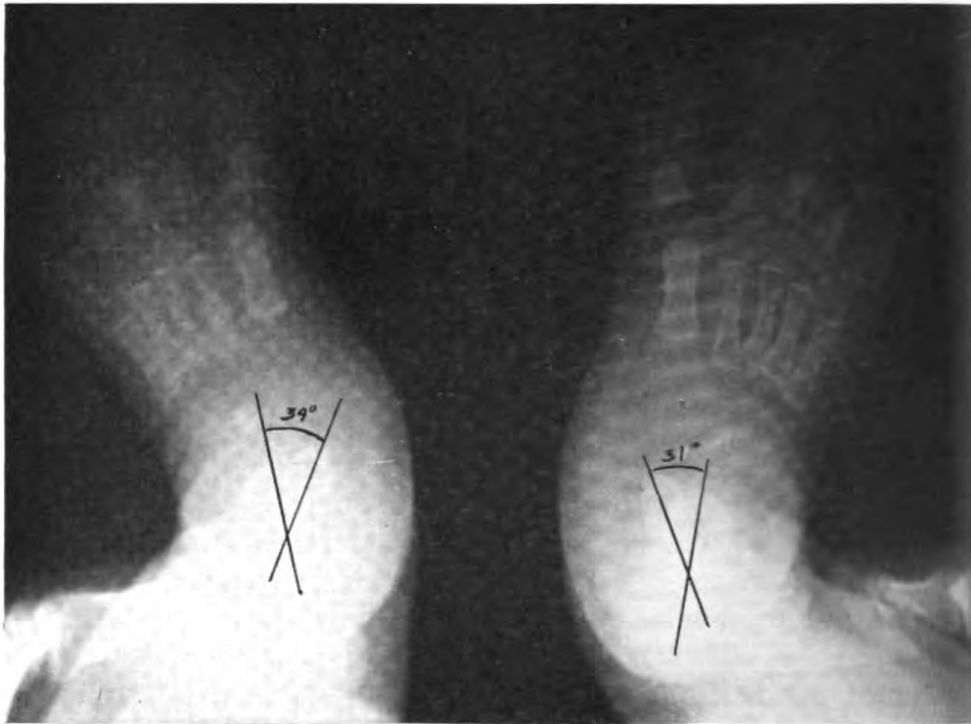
Roentgenogram taken after 11 weeks of treatment. The talus is now pointing toward the great toe. The midlines of talus and calcaneus now form an angle of about 30° to 35°.
